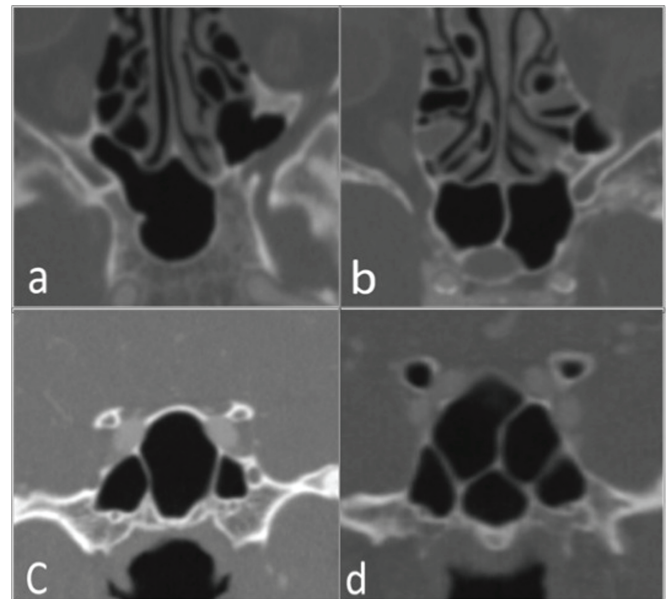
Number of the sphenoid septa. Axial computed tomography angiography (CTA) images demonstrate the cases who has no septum (a), one septum (b) and two septa (c). Coronal (CTA) image (d) shows the sphenoid sinus with multiple septa.
